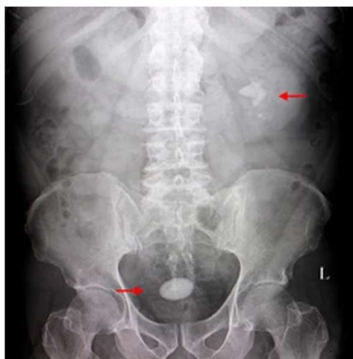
X-ray image of Urolithiasis
